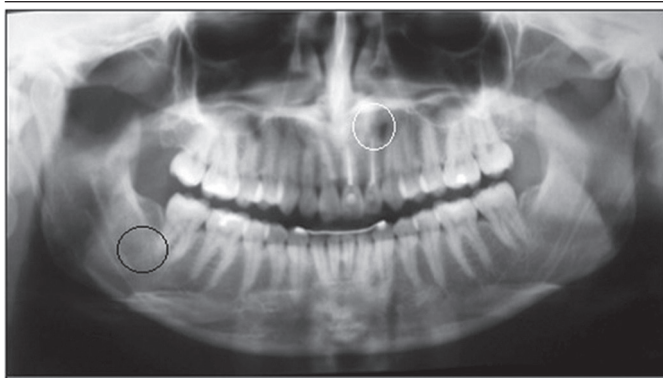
Post-treatment panoramic radiograph: ROI test (white circle) and final control (black circle) after the protocol of intralesional corticosteroid application
